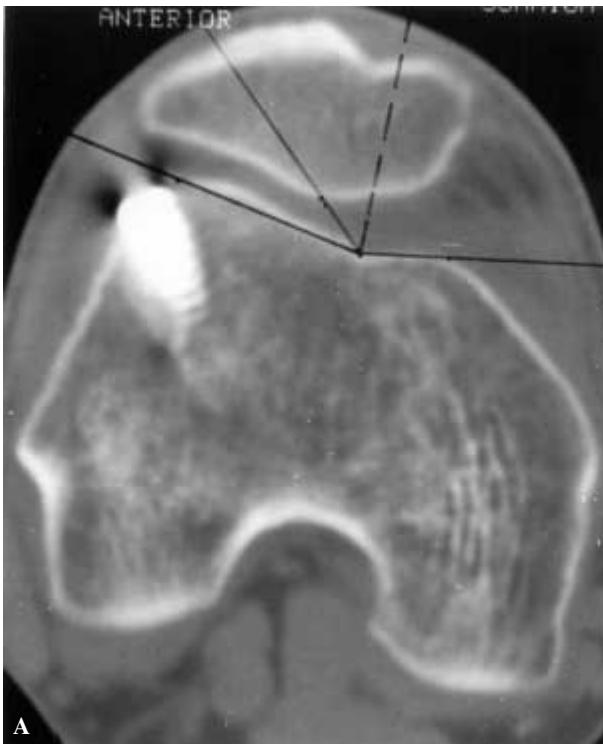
CT scan of the same patient, 6 months postoperative, in full extension. Note the abnormal congruence angle in this position.
